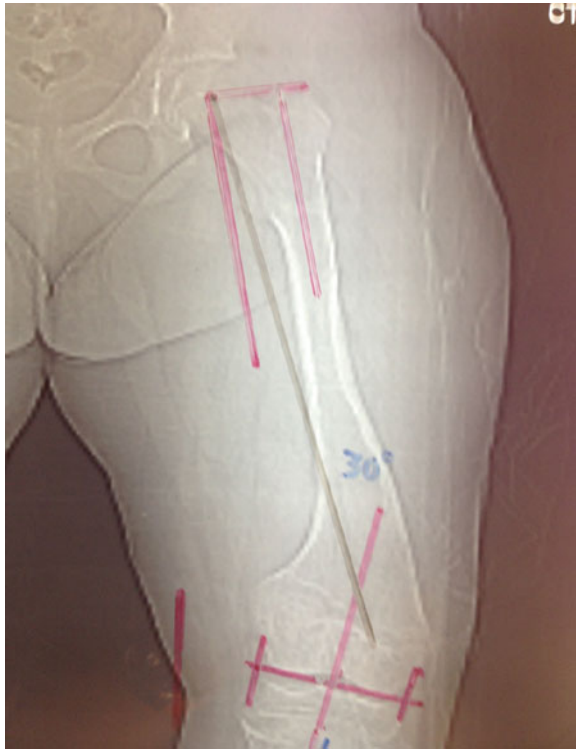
Mechanical axis preoperative planning, left femur, AP X-ray showing 30° varus deformity
